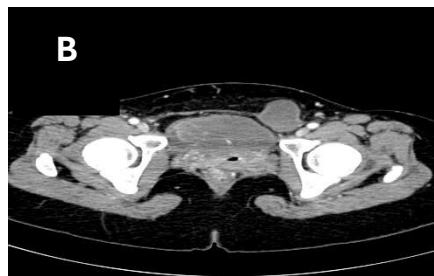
Contrast enhanced CT Abdomen & Pelvis in axial plane at pelvic region revealing a well-defined, non-enhancing thin-walled cystic lesion anteromedial to the left common femoral vessels. No evidence of solid component, bowel loop or omentum within the lesion. No communication with the peritoneum.
